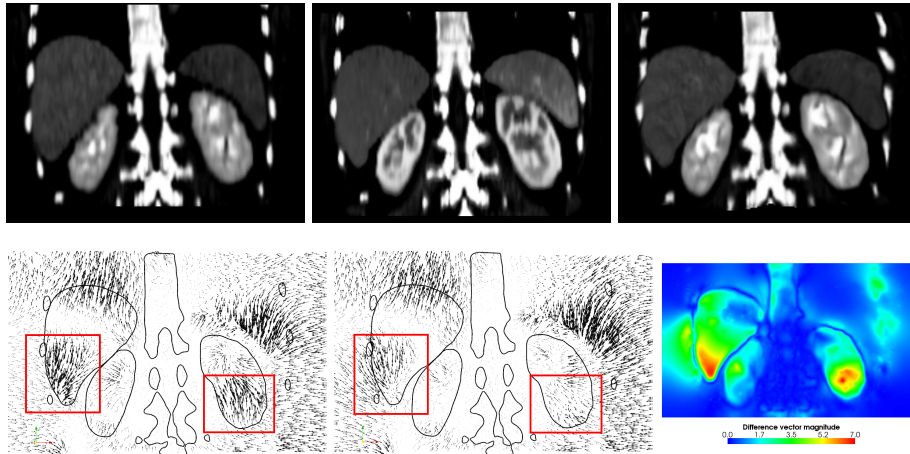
Top*: Coronal slice through the (left) moving, (center) target, and (right) transformed moving abdominal CT images using the sliding organ registration. *Bottom*: Coronal slice through the displacement fields from the (left) sliding organ and (center) diffusive registrations, with overlaid anatomical outlines for context, plus (right) the difference vector magnitudes between the displacement fields from the two registrations (best viewed in colour online).
